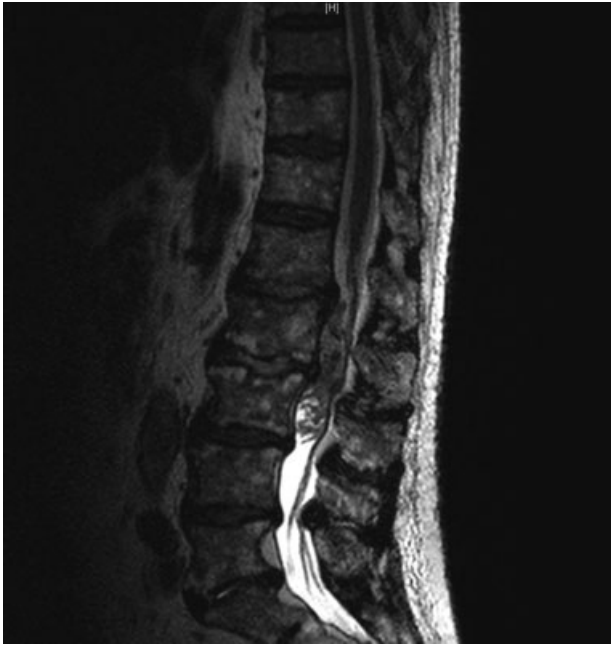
Sagittal T2-weighted lumbar magnetic resonance image. A large mass of unclear origin was identified at the L2-L3 level.
